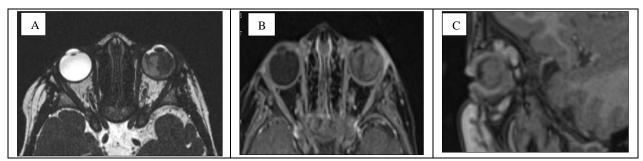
In axial CISS sequences (a) T1-weighted after gadolinium injection (b) and sagittal T1 without enhancment, a retinoblastoma is identified as discreet T1 hypersignal, isosignal T2, and with faint enhancement, along with subretinal seeding on retinal detachment.
